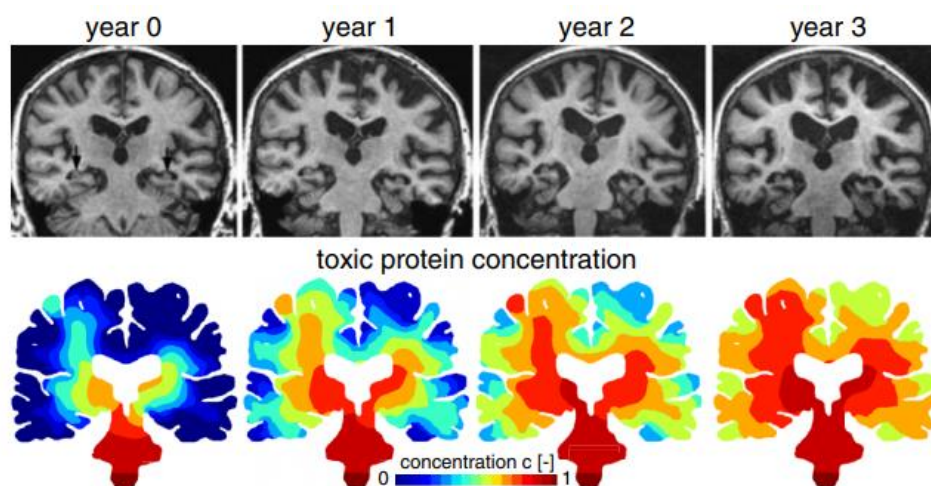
Evolution of Alzheimer's Disease. This figure shows a direct relation between progressive brain atrophy (top row), seen through Magnetic Resonance images, and respective increase and spread of toxic proteins, predicted through a propagation model (bottom row). As a result of the high toxic protein concentrations, it is often observed an unequivocal ventricular enlargement, widening of the cortical sulci and hippocampal atrophy (*Figure adapted from Weickenmeier et al., 2018*)¹³.
